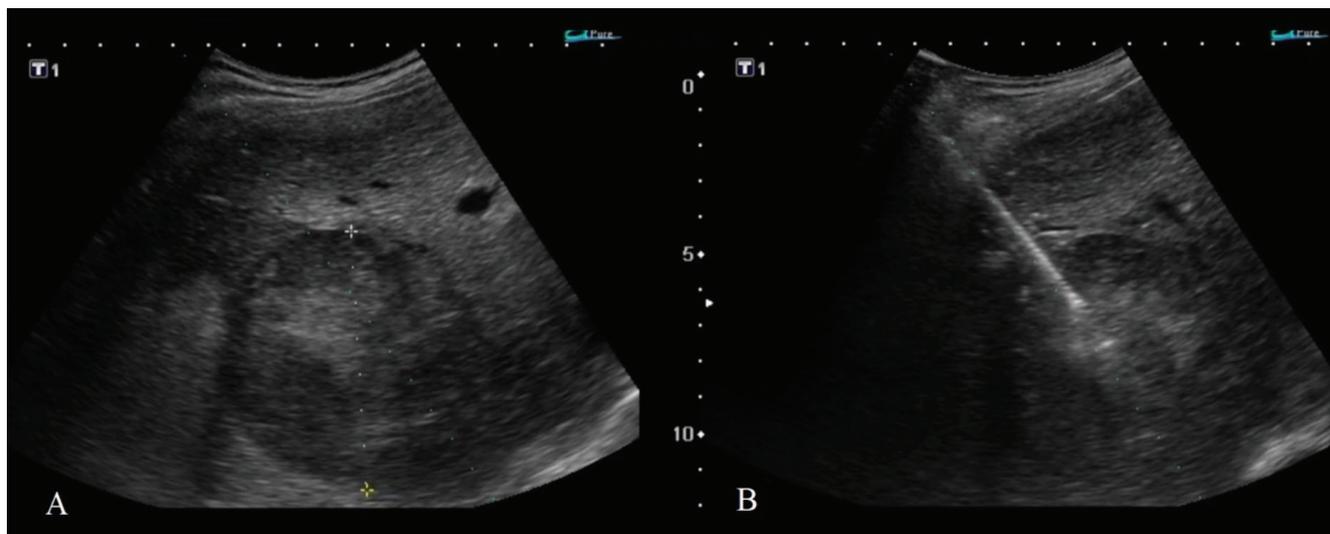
Ultrasound-guided core needle biopsy of the tumour (70 mm in diameter) of the right lobe of the liver. A) The measurement of the tumour. B) Core needle biopsy of the lesion.
